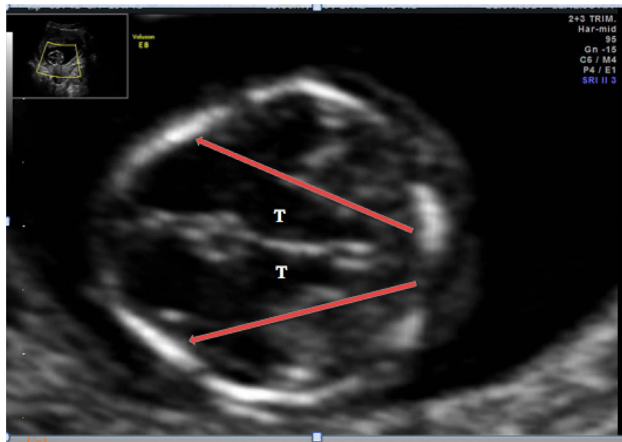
Ultrasound image showing the two thalami (T) and the two cerebral peduncles posteriorly with the aqueduct of Sylvius in between
